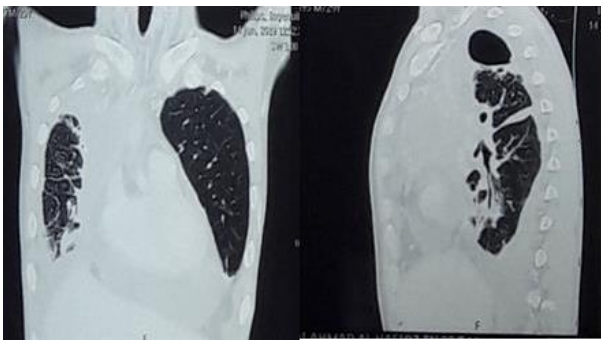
Chest CT scan without and with contrast evaluation after 3 cycles of BEP chemotherapy
